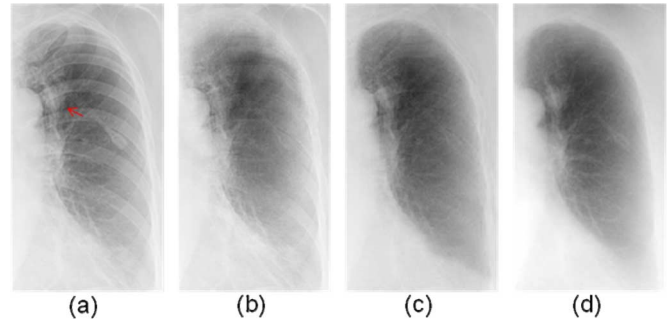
Results for abnormal chest radiographs with a nodule in the hilar region of the lung. (a) An original abnormal chest radiograph with a nodule (indicated by a red arrow), (b) a VDE soft-tissue image obtained by use of our original MTANN technique, (c) a VDE soft-tissue image obtained by use of our new MTANN technique, and (d) the corresponding “gold-standard” dual-energy soft-tissue image.
